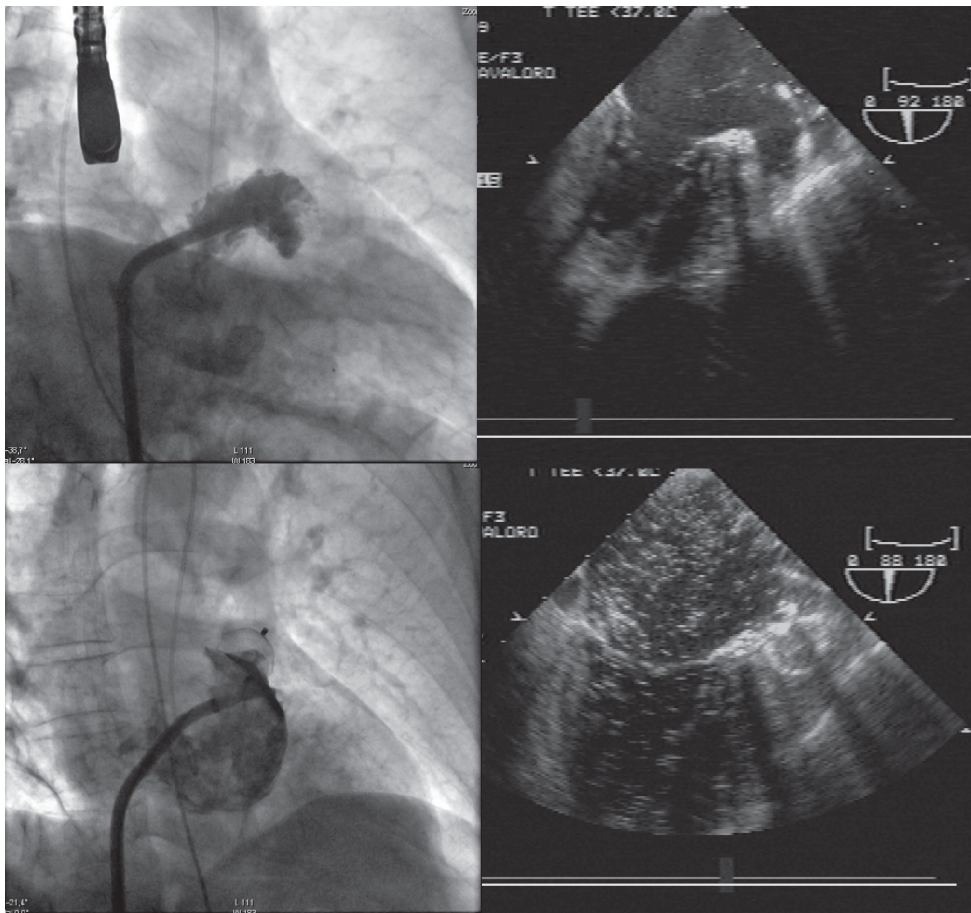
A. Angiography prior to closure; B. Transesophageal echocardiography prior to closure; C. Postimplantation angiography of device; D. Contrast transesophageal echocardiography after implantation. Note in photos c and d the absence of passage of angiographic and echocardiographic contrast to left atrial appendage, confirming the closure of the same with the implanted device.
